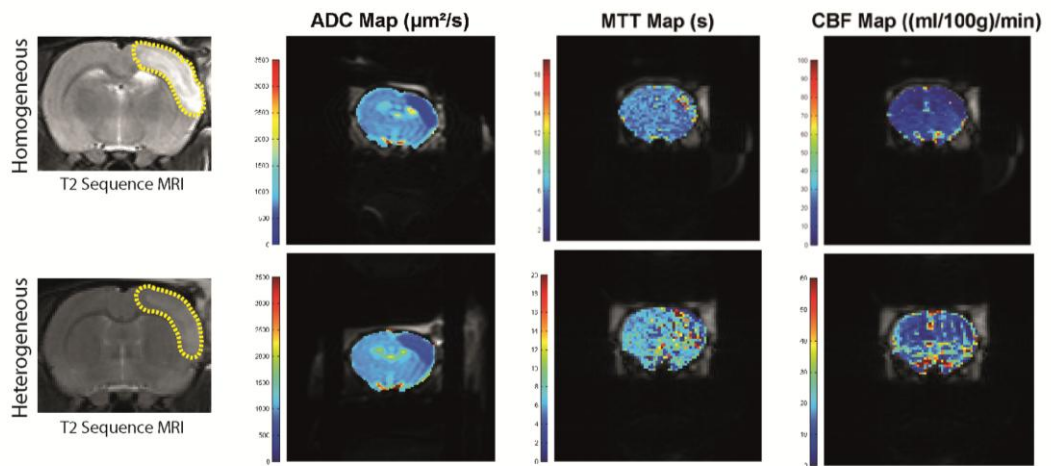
DWI AND PWI MRI OF HOMOGENEOUS AND HETEROGENEOUS PATTERN.
